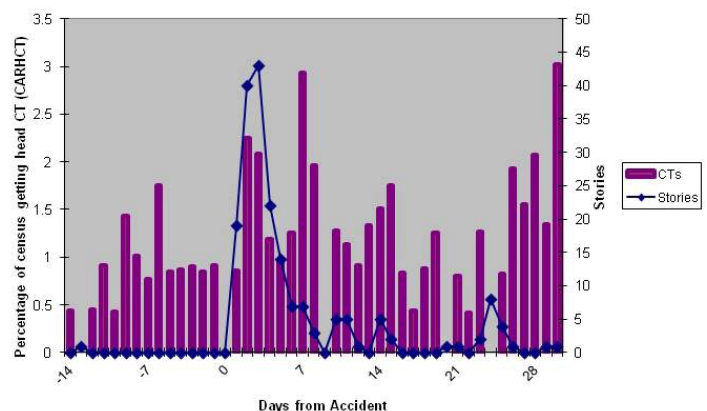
Percentage of census getting head computed tomography.
